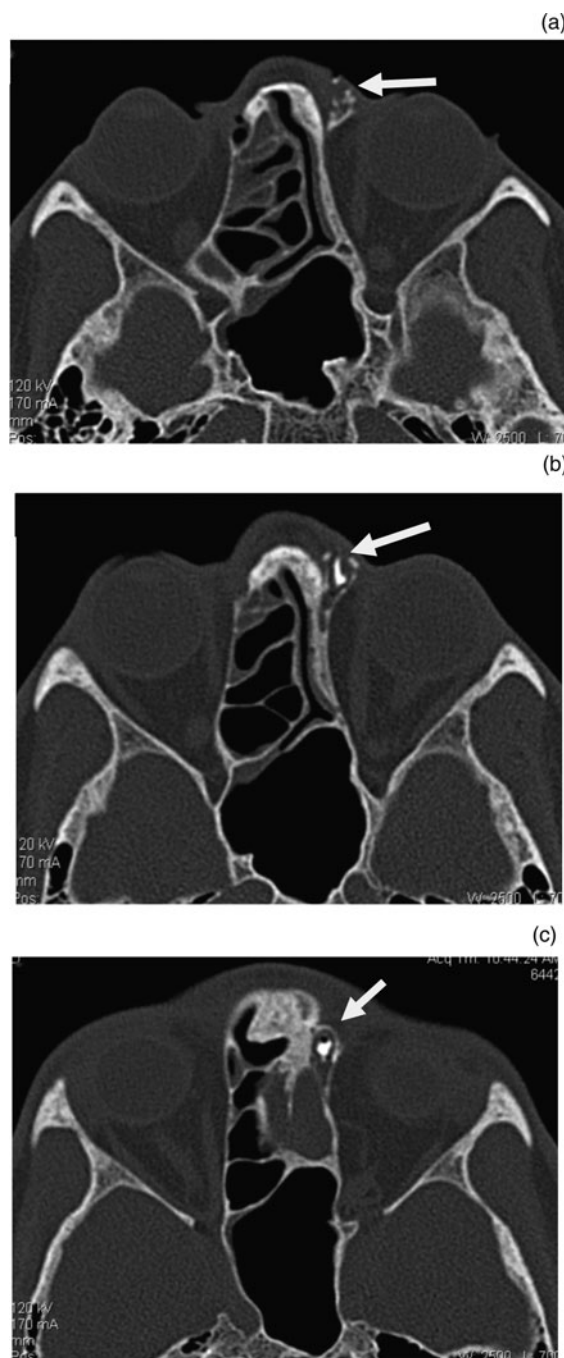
(a) Axial plane image (arrow indicates proximal end of the nasolacrimal duct) and (b) coronal plane image (arrow indicates proximal end of the nasolacrimal duct) from computed tomography dacryocystography show non-passage of contrast beyond left lacrimal sac.
